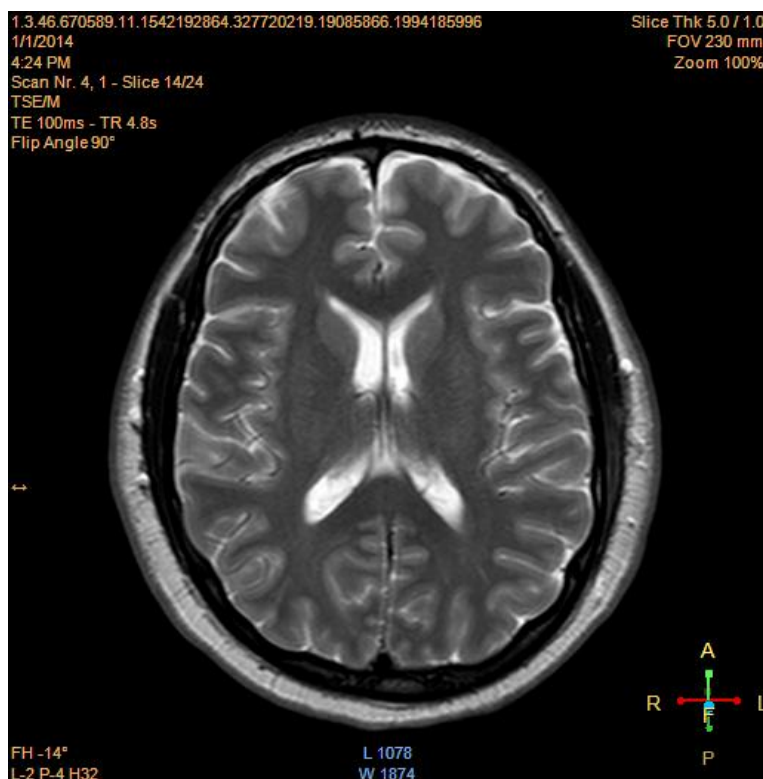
MRI Brain showing bilateral basal ganglia calcification.
